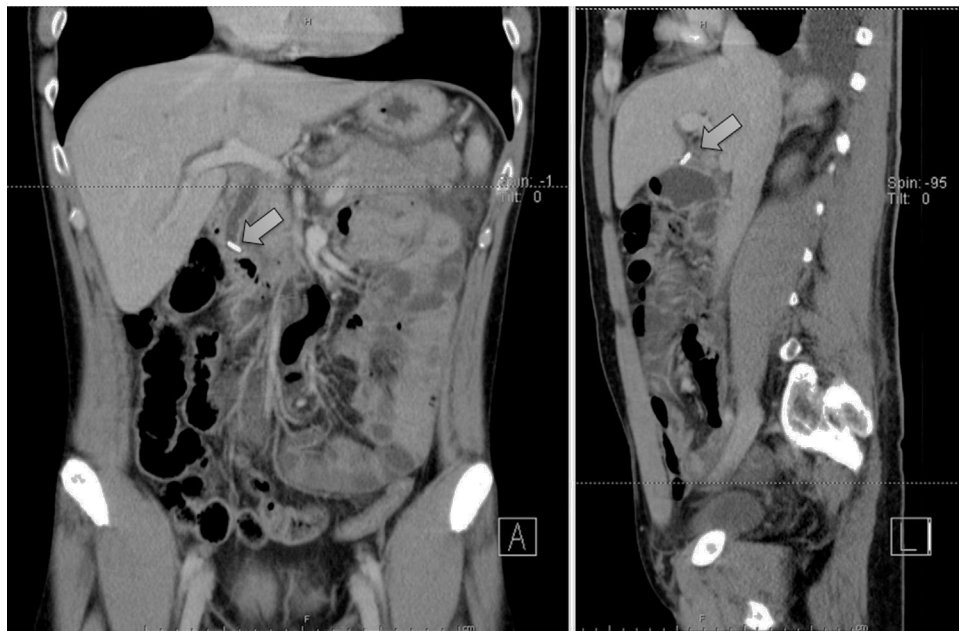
CT scan demonstrating a surgical clip in the common bile duct.
